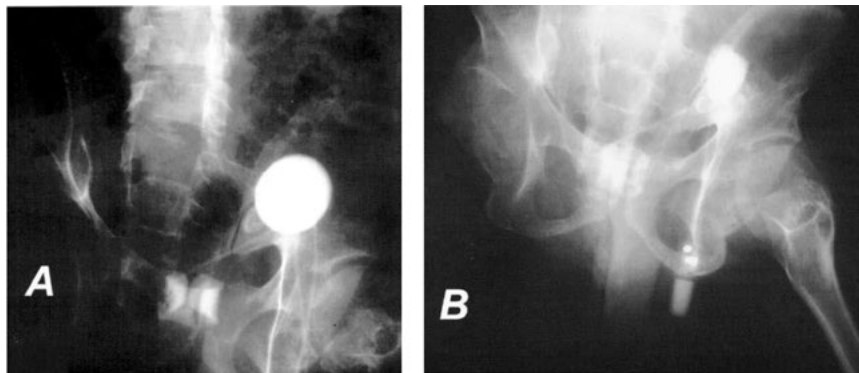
Young spina bifida patient who had a bladder neck artificial sphincter implanted. After more than 10 years, he became incontinent. Early abdominal plain film, A, shows a full reservoir. After leakage started abdominal plain film, B, demonstrates loss of fluid from the reservoir.
